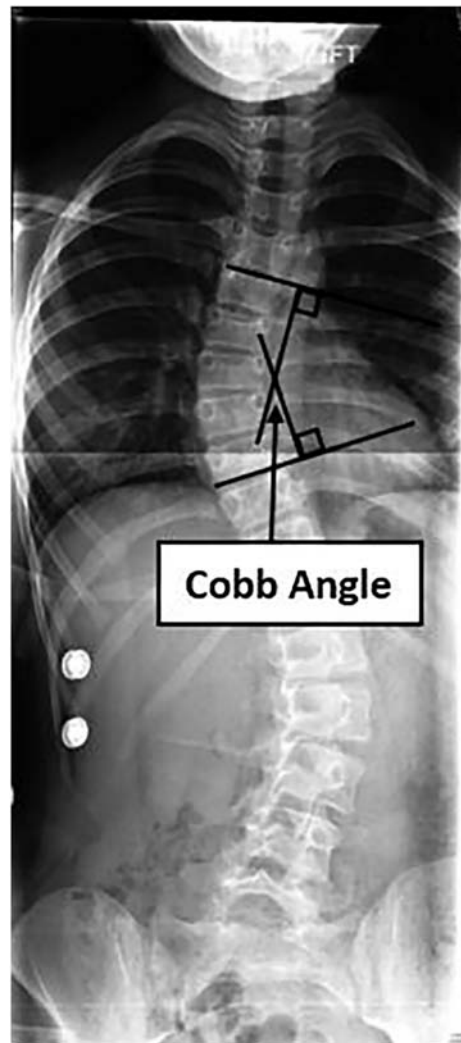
Alternate representation of the Cobb angle. Because the lines often extend beyond the work surface, 2 additional lines are drawn at 90° from the first 2, and the subsequent intersecting angle is measured. This figure was retrieved from the Open-i service of the National Library of Medicine at https://openi.nlm.nih.gov/detailedresult.php?img=PMC2527554_1748-7161-3-11-1&query=scoliosis+x-ray&req=4&npos=706 (last accessed July 14, 2017). License type Attribution 2.0.
